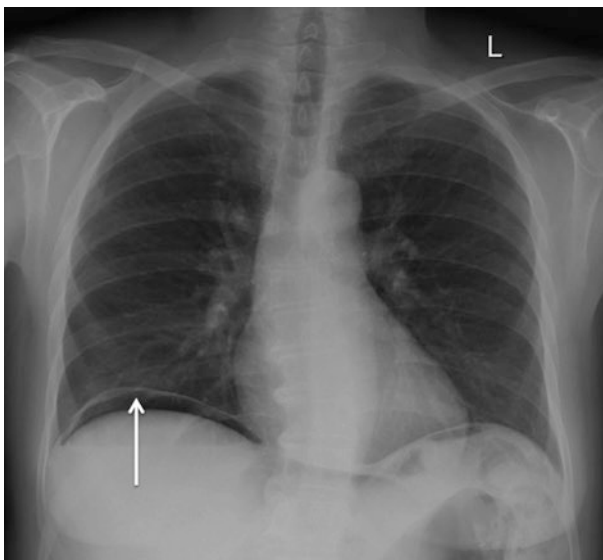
Erect chest radiograph demonstrates free intra-abdominal air as a lucent crescent beneath the right hemidiaphragm (solid arrow)
